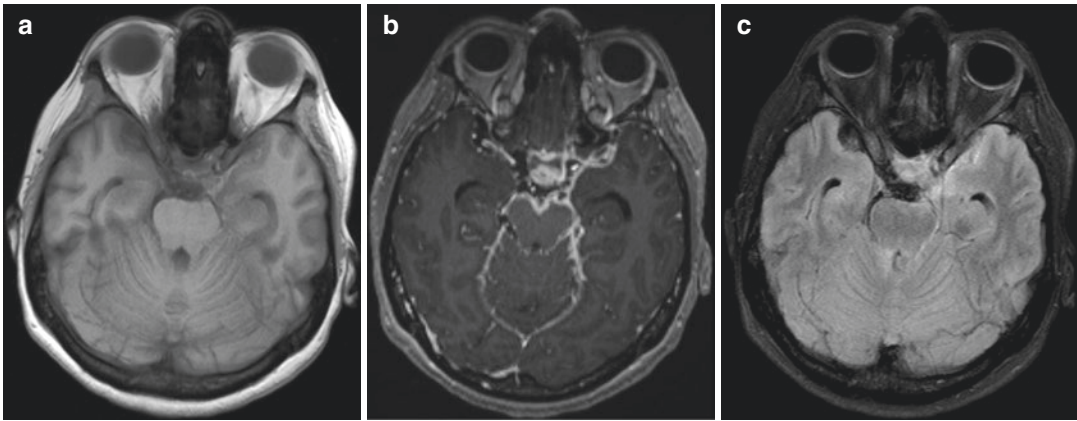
Axial pre- (a) and post-contrast (b) T1-weighted and FLAIR (c) images through the base of the brain demonstrate thick, basilar meningeal enhancement in a 34-year-old female with AIDS, found to have TB meningitis
